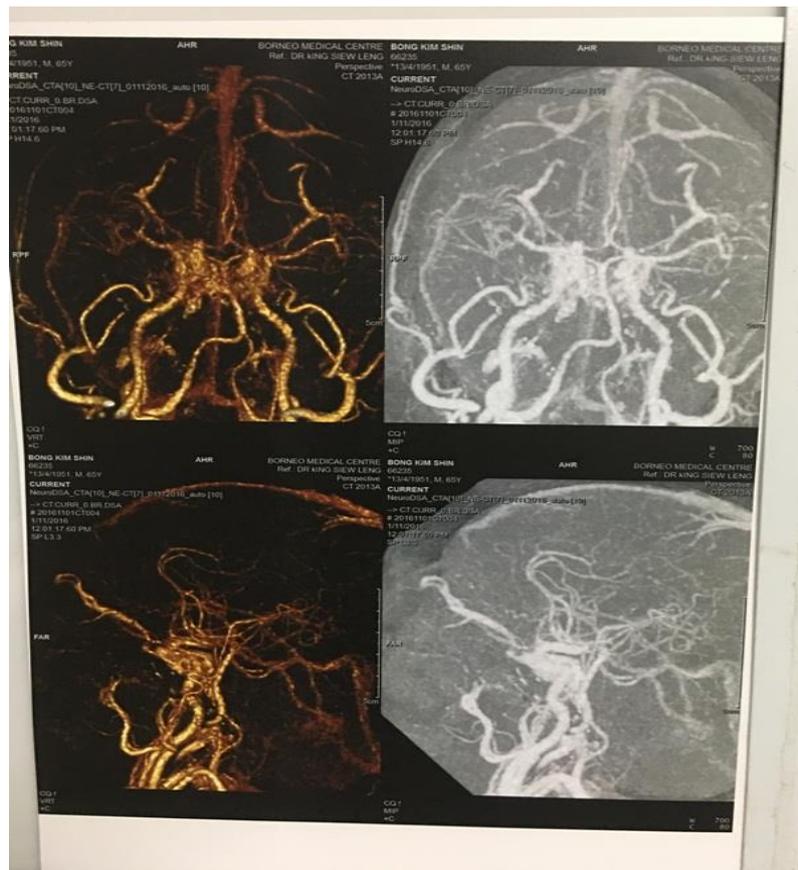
CT angiogram showed bilateral symmetrical bulky and prominent cavernous sinuses, with patent contrast opacification. Right cavernous sinus measures 1.2cm width and Left 1.1cm width. Bilateral symmetrical enlarged and engorged superior ophthalmic veins. No obvious large external carotid artery branches communicating into orbit. Both intracranial distal internal carotid arteries are grossly normal
